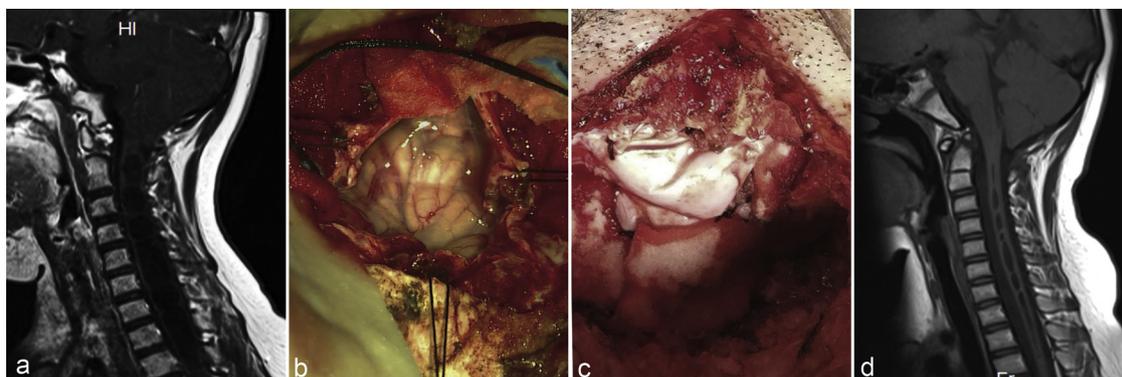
A 34-year-old CM-I male patient with a 1-year history of right upper limb weakness. (a) Preoperative T1-weight image showed CM-I with a syrinx from C2 to T9. (b) After Y-pattern cutting of the dura mater, the arachnoid swelling above the cerebellar tonsils removed. (c) The artificial dura mater was carefully sutured, expanded and decompressed. (d) Follow-up MRI examination 0.5 year after surgery showed a wide cisterna magna and obvious regression of syrinx. The symptom of weakness was alleviated.
